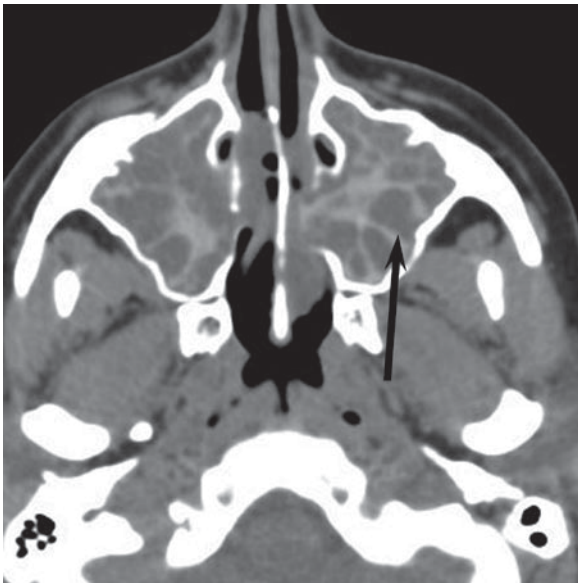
Hyperdense secretions. Axial CT shows innumerable polyps in the maxillary sinus in a patient with NP. Some of the polyps are pedunculated (*arrow*), distinguishing them from MRC. The inspissated secretions between the polyps have increased density, which reverses the normal density pattern seen in Fig. 6.1
